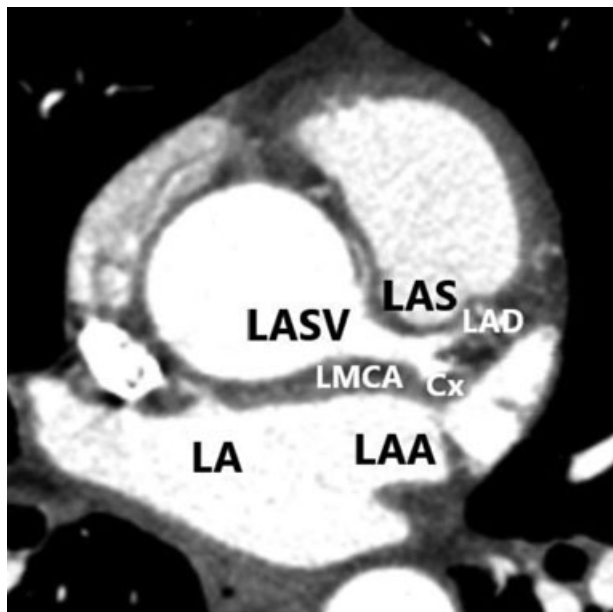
Axial CT image of the heart—transverse reconstruction showing anatomic relation of LMCA to the adjacent structures. The distance from LMCA to LAA and LAS is 5.15 and 2.30 mm, respectively. CT, computed tomography; Cx, left circumflex coronary artery; LA, left atrium; LAA, left atrial appendage; LAD, left anterior descending artery; LAS, left adjacent sinus of the pulmonary artery; LASV, left aortic sinus of Valsalva; LMCA, left main coronary artery
